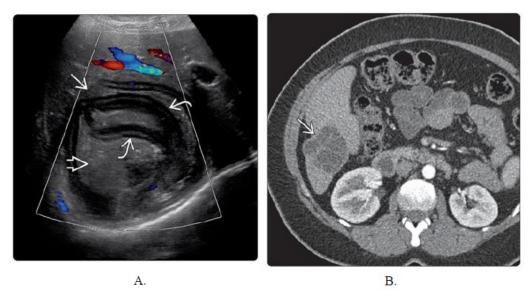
A. Oblique abdominal color Doppler USG shows hepatic echinococcal cyst (arrow) and fine echogenic debris (hydatid sand) (hollow arrow). Separation of the endocyst membrane causes the membranes to float within the pericyst, what we call the "water lily" sign (curved arrow). B Axial abdominal contrastenhanced CT shows a multiloculated cystic mass (arrow) in the right lobe of the liver.
